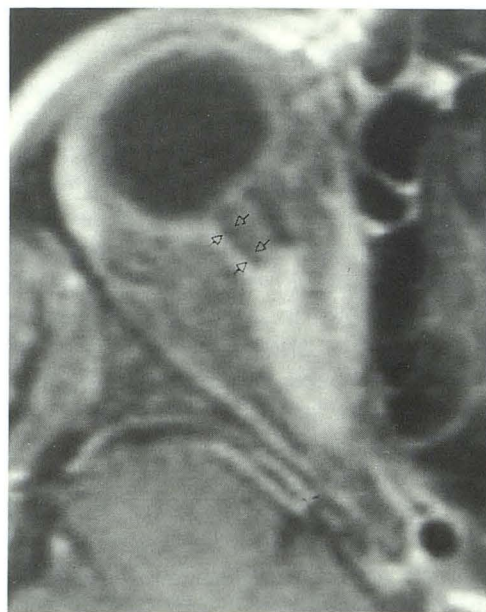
T1-weighted 700/12/2 (TR/TE/excitations) post-gadolinium 3-mm thick axial scan obtained with fat suppression in a head coil. Note periopic enhancement of the mid portion of the optic nerve which reflects a meningioma. The anterior 6 mm of the nerve appears normal with two adjacent low intensity linear bands representing dilated perineural CSF-containing spaces (arrows).
